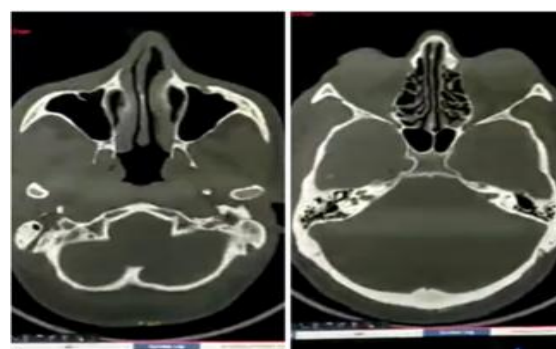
CT scans of the paranasal sinuses (Image 3a), neck (Image 3a)
